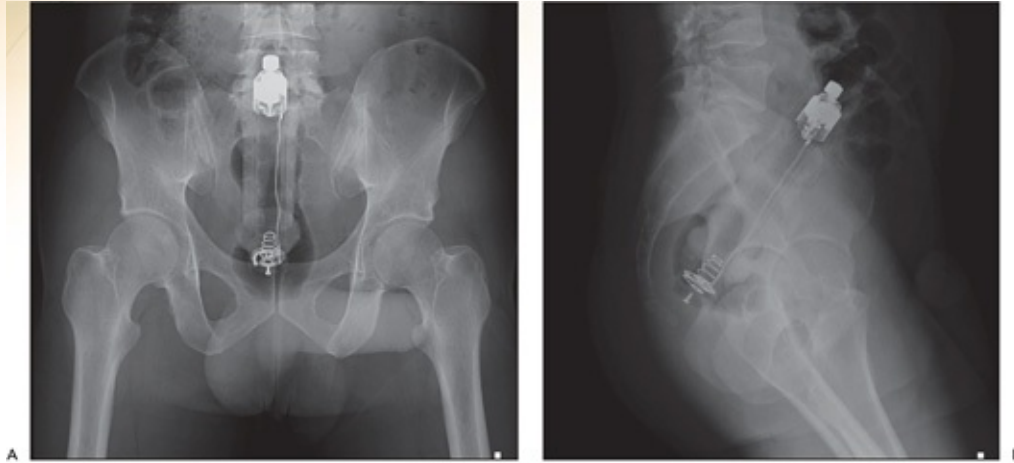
Radiographs of pelvis demonstrating a rectal foreign body. A: AP. B: Lateral.
